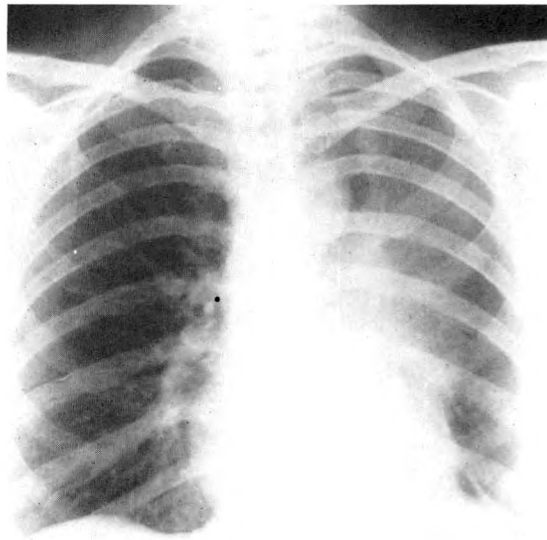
Case II. Posteroanterior chest roentgenogram (Aug. 14, 1963) shows haziness extending from left hilus into left lung field. The main pulmonary arteries cannot be identified. The vascular shadows fan out from the hilus and are much reduced in size, number and caliber. The radiolucent area lateral to and above the aortic knuckle represents herniation of the right upper lobe through the anterior mediastinum.
